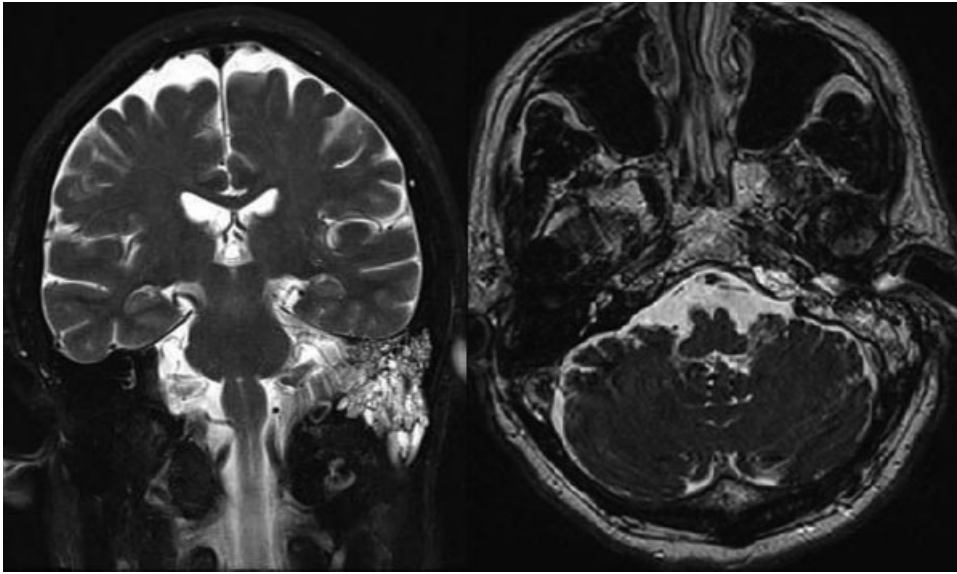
Magnetic resonance imaging showing a left temporal bone filled with cerebrospinal fluid.
